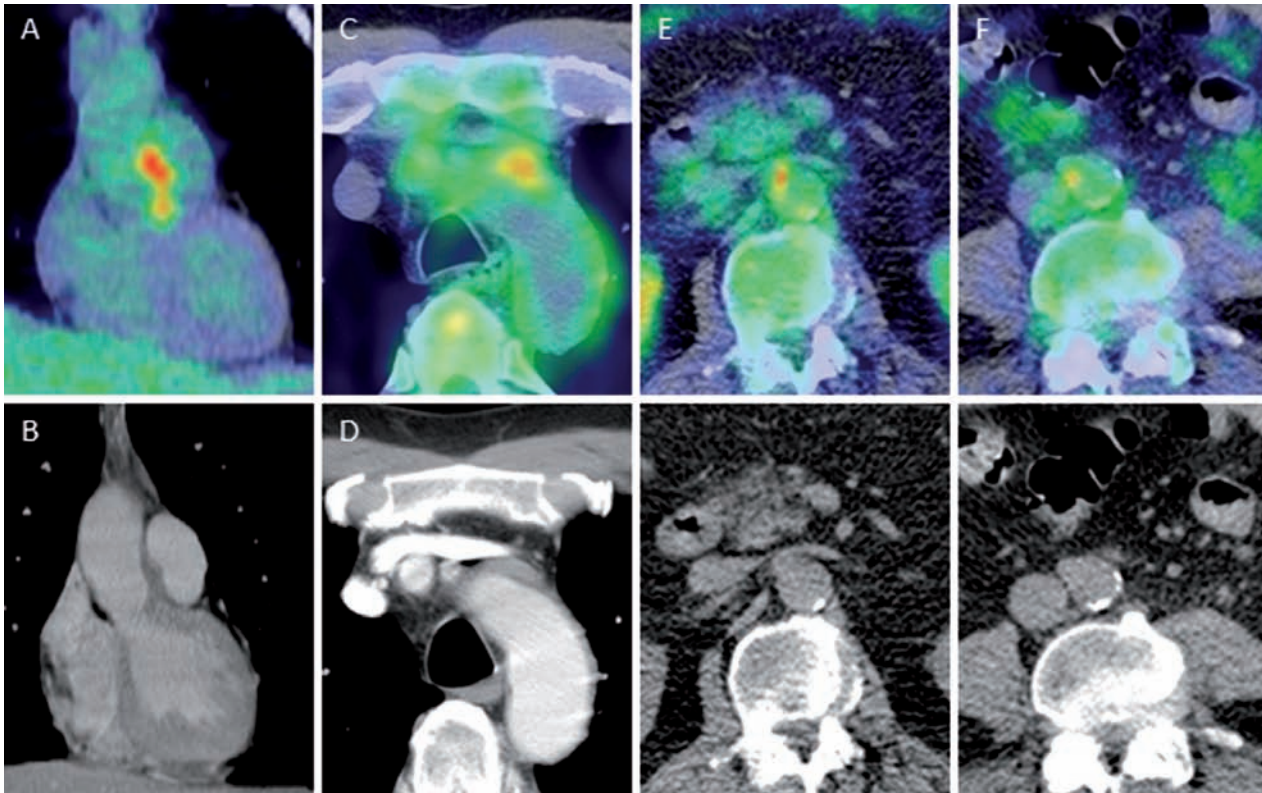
Arterial wall involvement with GPA. Patient no. 8 shows intensely FDG avid fusiform non-calcified non-circumferential thickening of the ascending aorta wall just distal to the aortic valve, between the aorta and main pulmonary artery seen on coronal fused PET/CT (A) and diagnostic IV contrast enhanced coronal CT performed 1 day earlier (B). This thickening and activity slowly resolved on follow-up PET/CT scans with therapy for GPA. This patient also had lymphoma, and this tissue was never directly biopsied, so the diagnosis of GPA in this location is not certain. Rarely lymphoma can involve vessel walls in a similar manner. Patient no. 9, at the time of diagnosis of GPA, showed intensely FDG avid fusiform non-calcified non-circumferential thickening of the anterior aortic arch extending into the wall of the left subclavian artery as seen on axial PET/CT (C) and IV enhanced axial diagnostic CT (D) that resolved on follow up imaging with therapy for GPA. Three years later, at the time of a flair in GPA activity seen elsewhere in the lungs on FDG PET/CT (9/27/10 on figure 5), there was new focal moderately FDG avid fusiform non-calcified non-circumferential thickening in the right wall of the aorta at the level of the right renal artery and at the aortic bifurcation seen on axial PET/CT (E & F). This patient had a history of melanoma, but these lesions resolved with therapy for GPA, which would not be expected for melanoma. Although one might question whether the lesions represented in E & F are focal vulnerable plaque from atherosclerotic disease, the lesions bulged out the contour of the aorta and later shrank with GPA therapy, which would be uncharacteristic of atherosclerosis
